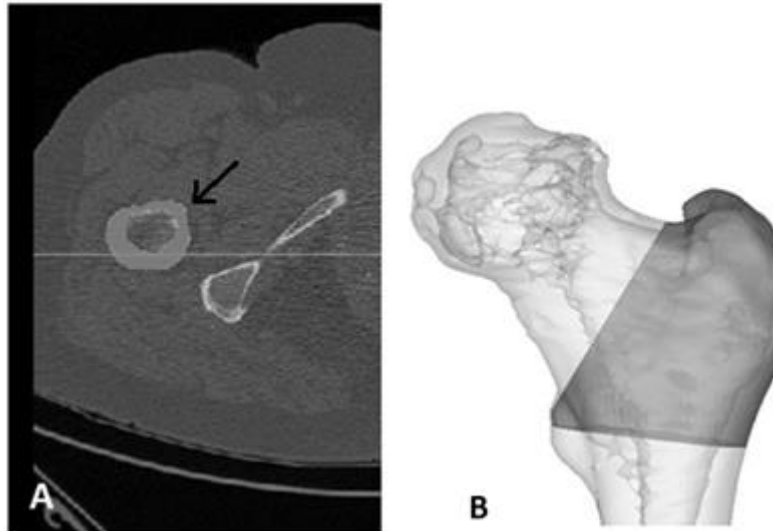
A) Axial view of one slice of the CT-data from a patient, and B) the 3D view of the region of interest for BMD calculations. The arrow in the center of image A points to the area belonging to the mask.
